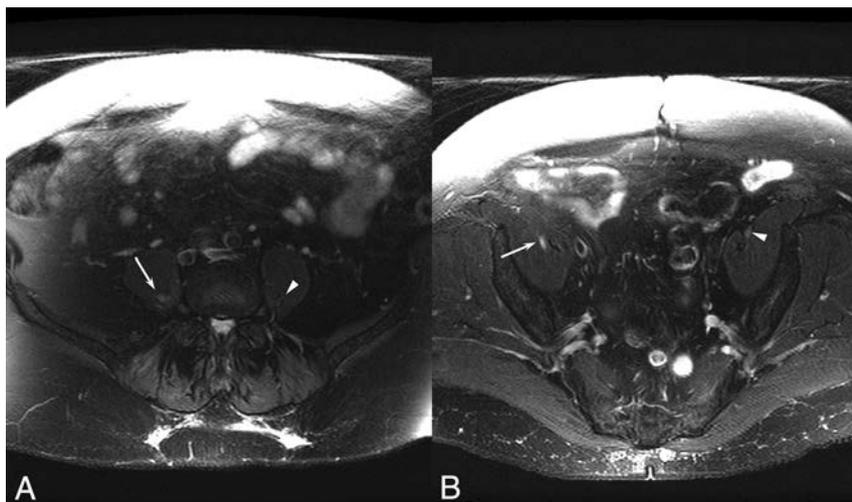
A 70-year-old woman with a right lumbar zoster-associated plexopathy. *A*, Axial T2-weighted image demonstrates increased T2 signal in the right lumbar plexus (*arrow*) compared with the left lumbar plexus (*arrowhead*). *B*, Increased T2 is also noted more distally in the right femoral nerve (*arrow*) compared with the unaffected left side (*arrowhead*).
